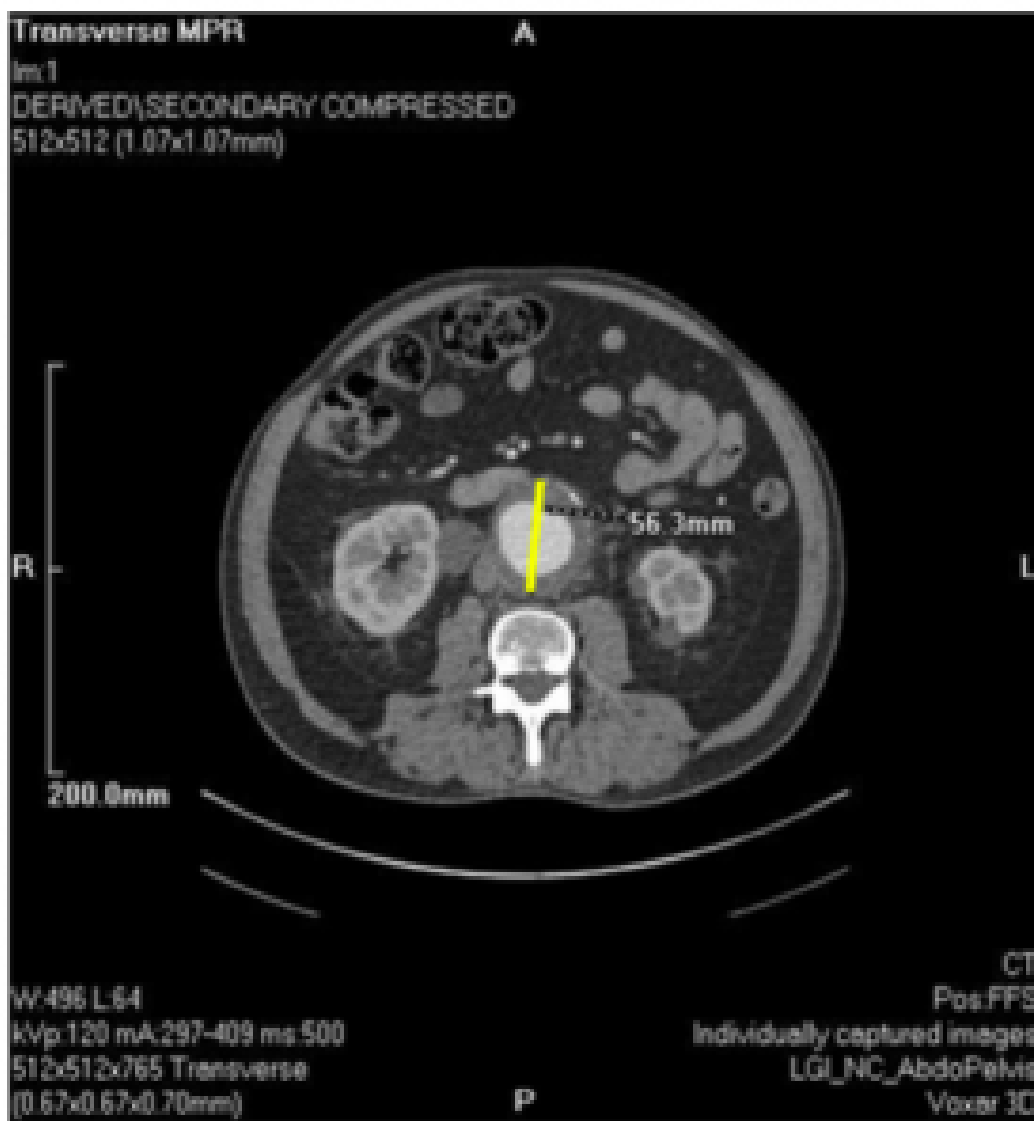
CT aortogram revealing the 5.6 cm (yellow line) anteroposterior diameter AAA.¹
